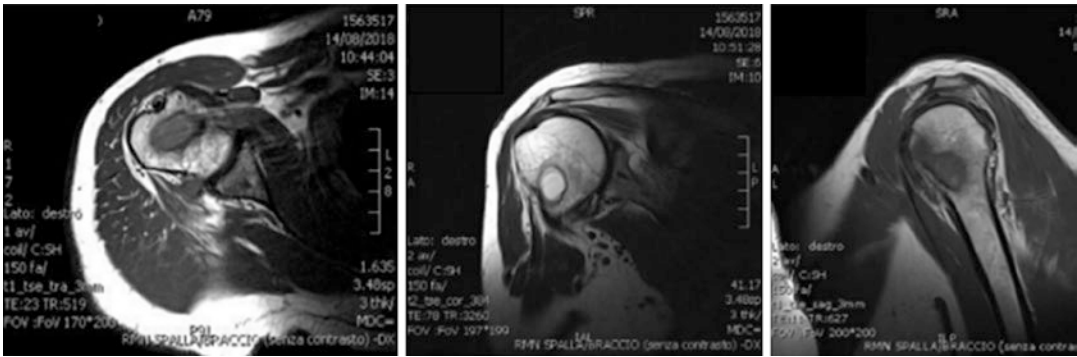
MRI control: 1 month after surgery
